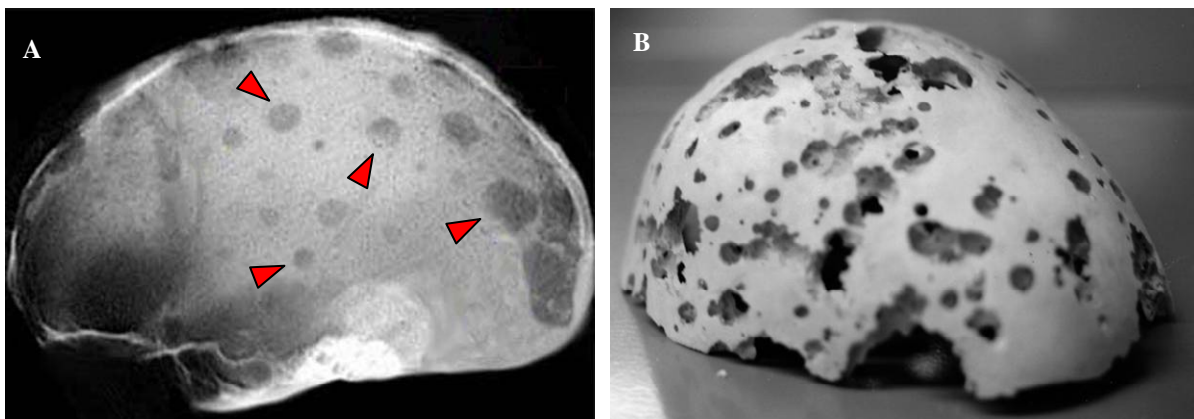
Typical bone lesions induced by multiple myeloma. A) The skull X-ray shows “punched out lesions” (arrowheads) in the skull, which are characteristic of multiple myeloma. B) Gross examination of the skull reveals severe bone destruction induced by MM.
